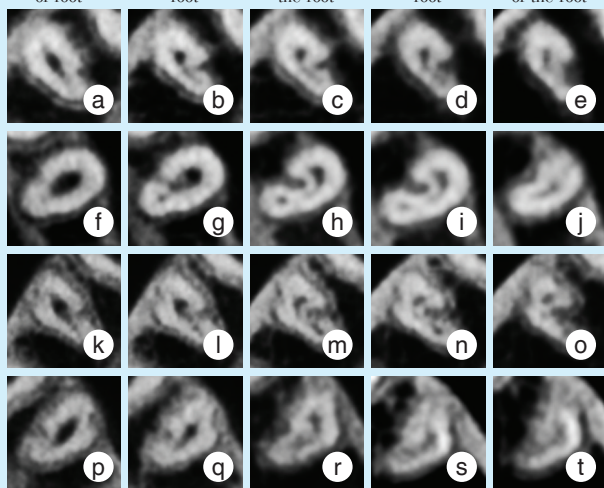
CBCT cross-section of various C-shaped root canal configurations of mandibular premolars
